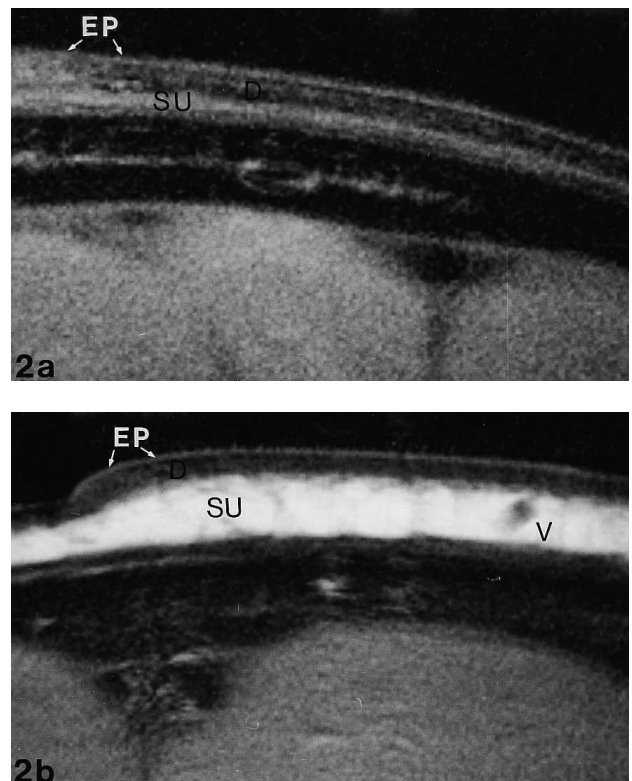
An 11-year-old boy with clinical stage 2 progressive facial haemiatrophy. Magnetic resonance imaging stage 3. MRI of the skin (frontal bone). T1-weighted transverse image (500/25, ACQ 3, matrix 256×256 , slice thickness 2 mm). (a) The subcutis can be distinguished with definitely reduced thickness at some sites only. Minimal chemical shift artifact. Reduced dermal thickness and loss of interdigitating. (b) Unaffected contralateral side. Three-layered skin: hyperintense epidermis, hypointense dermis; underlying subcutis. EP: epidermis; D: dermis; SU: subcutis; V: vessel.
